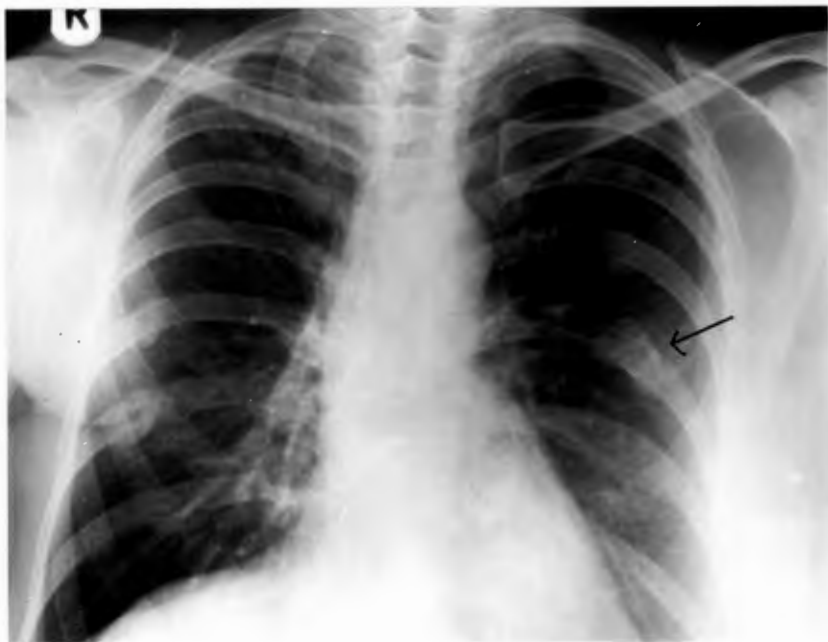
On the 21st May, 1973, 2 months after trans-frontal hypophysectomy, re-calcification is clearly occurring. A later radiograph taken in early July shows even more impressive bone healing.
